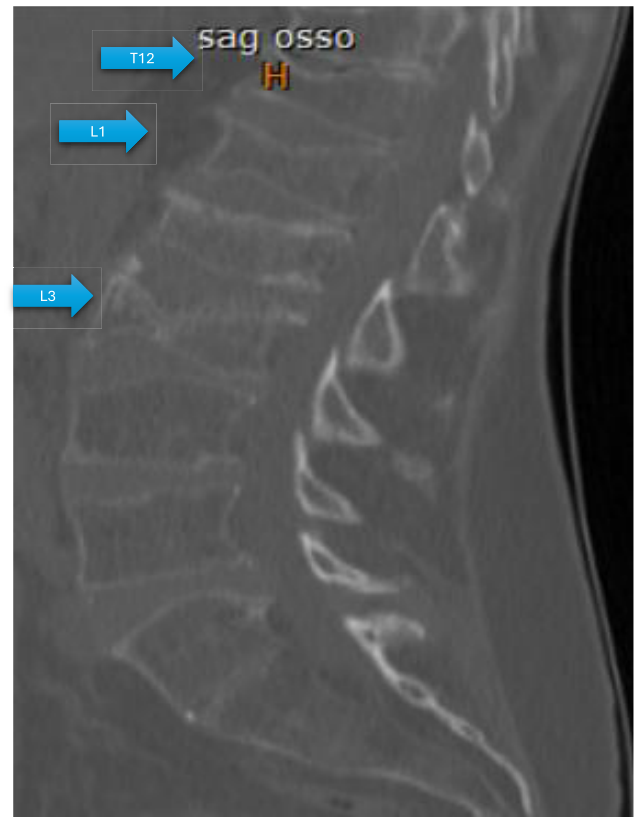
Computed tomography scan of the lumbar spine. The arrows highlight morphometric vertebral fractures of T12, L1, and L3 in the absence of apparent trauma.
